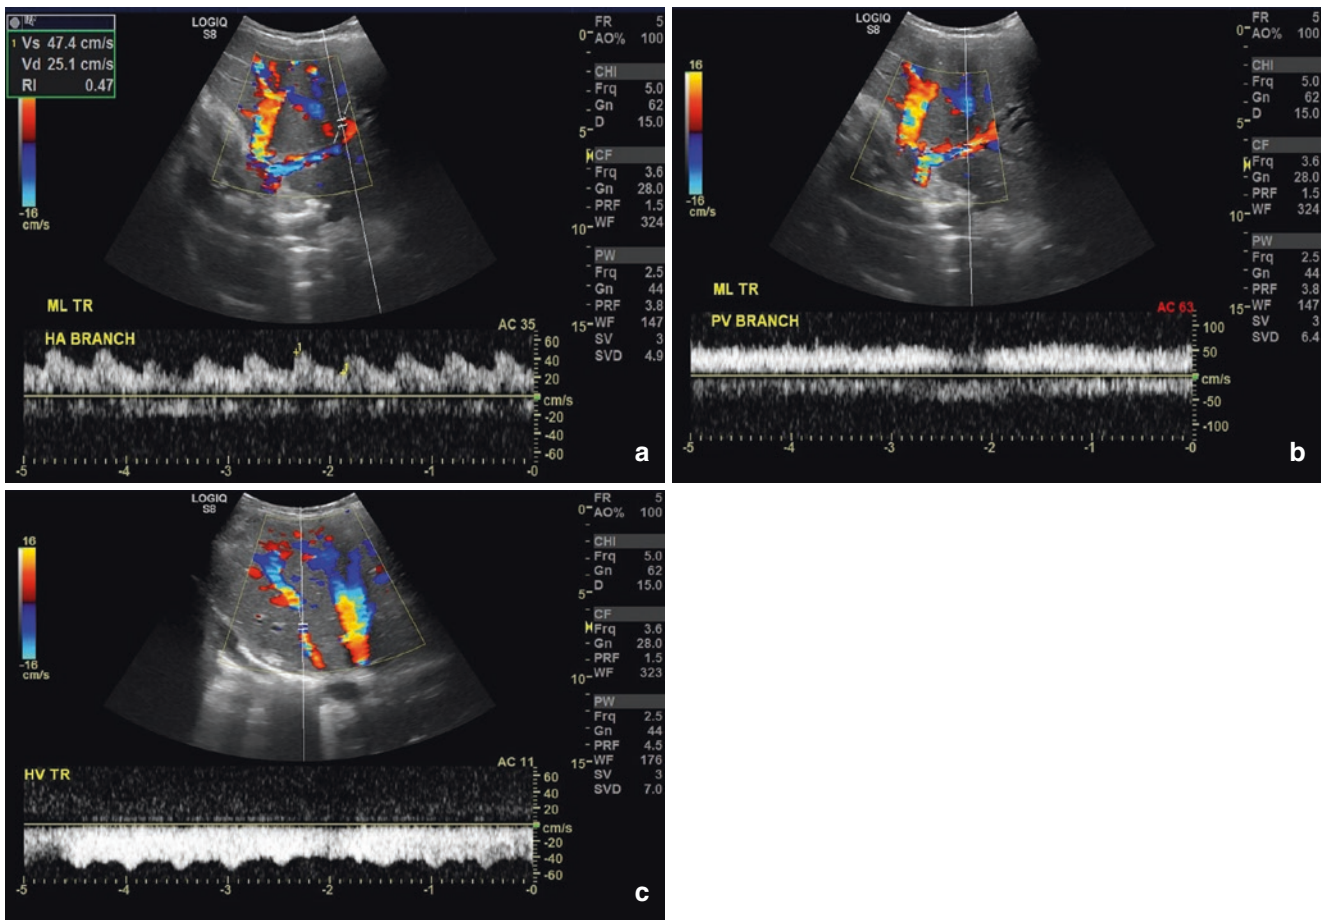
Ultrasound Doppler of the transplant liver reveals normal Doppler traces of (a) hepatic artery, (b) portal vein and (c) hepatic vein with normal liver echogenicity
